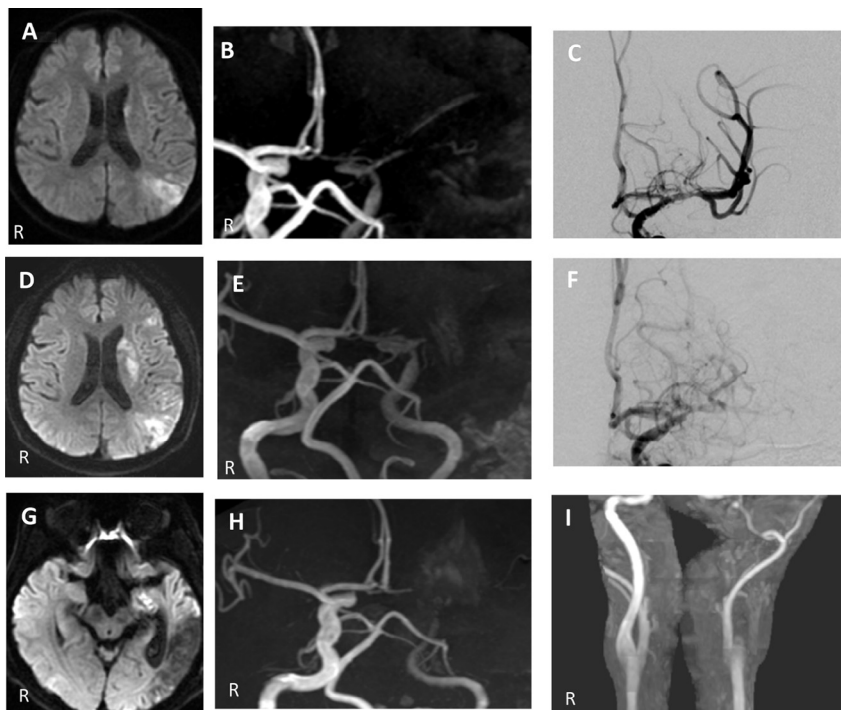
(A) Diffusion-weighted MRI (DWI) at the first admission. (B) MRA at the first admission. (C) Anteroposterior (AP) view of the left internal carotid angiograph showing middle cerebral artery stenosis 1 day after the onset of the first stroke. (D) DWI on day 7 after the first stroke. (E) MRA on day 7 after the first stroke. (F) AP view of the left internal carotid angiograph showing middle cerebral artery occlusion on day 7 after the first stroke. (G) DWI at the second admission. (H) MRA at the second admission. (I) MRA 2 years after the first stroke. Abbreviations: DWI, diffusion-weighted imaging; MRA, magnetic resonance angiography; MRI, magnetic resonance imaging.
